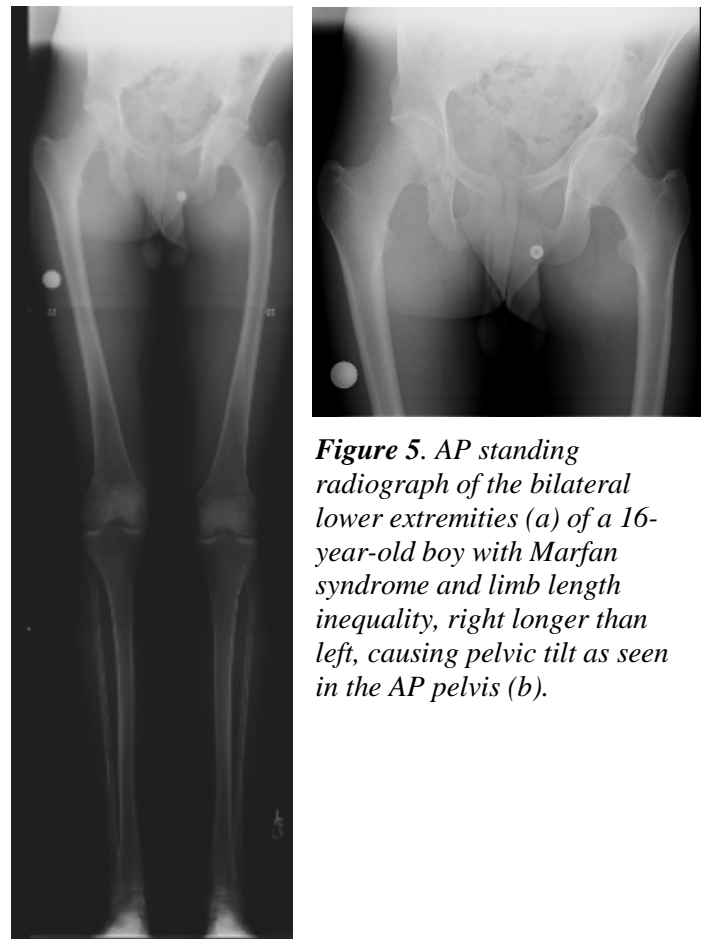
AP standing radiograph of the bilateral lower extremities (a) of a 16-year-old boy with Marfan syndrome and limb length inequality, right longer than left, causing pelvic tilt as seen in the AP pelvis (b).
